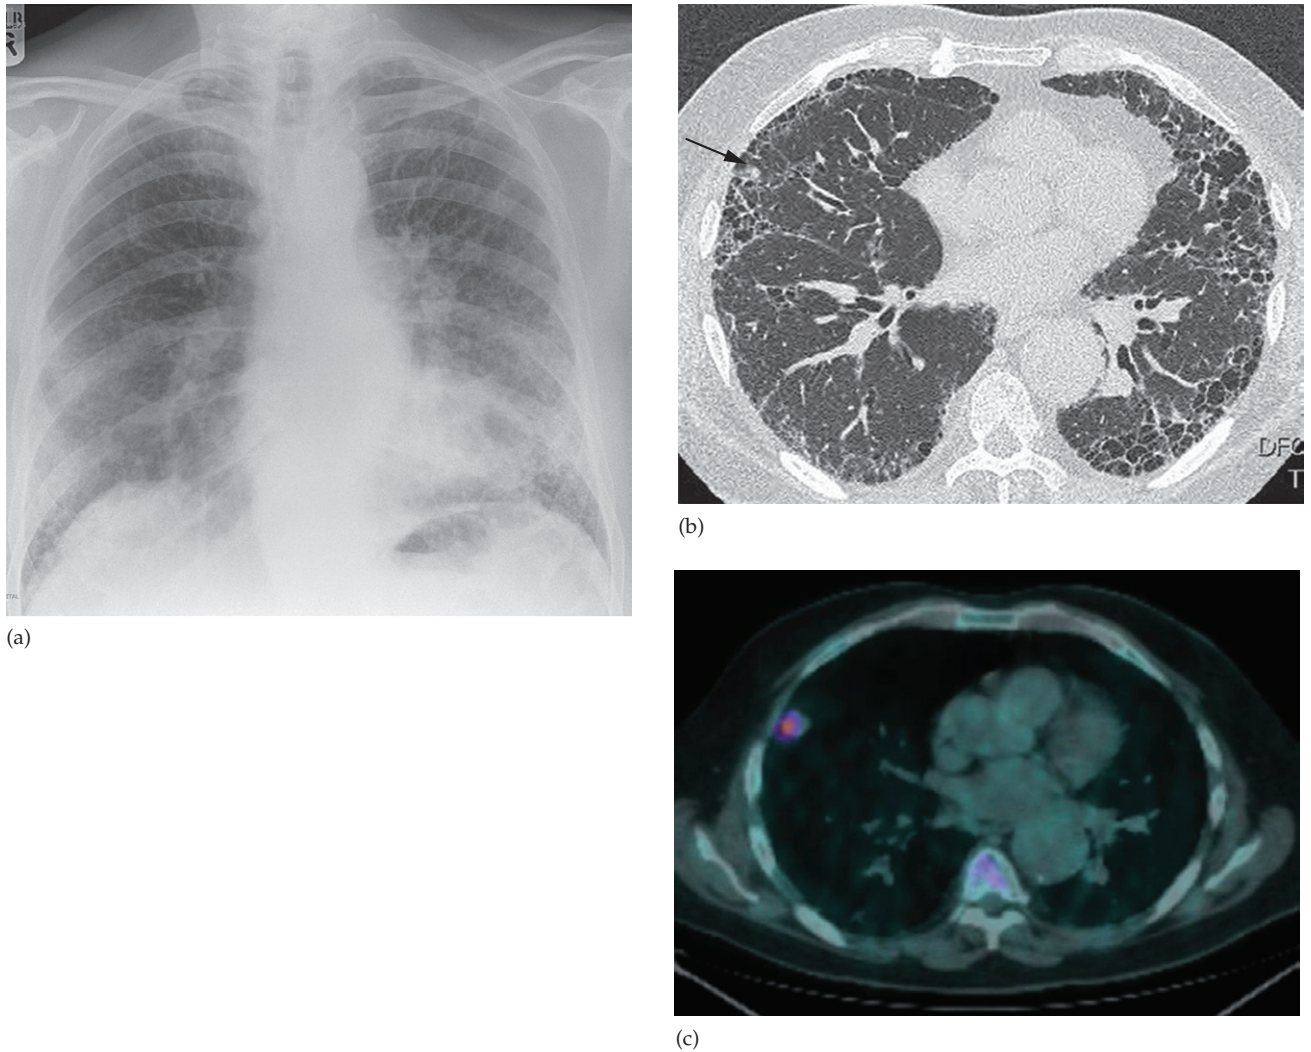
Idiopathic UIP. (a) CXR showing reticulonodular opacifying (honeycomb lung) with basal predominance. Scleroderma, rheumatoid arthritis and drug-induced interstitial fibrosis give a similar picture. (b) HRCT showing the typically subpleural honeycomb distribution in the lungs. (c) Note also the small peripheral nodule in the right lung (arrow), which on FDG-PET/CT was confirmed to represent a lung cancer, which has a higher incidence in these patients.
